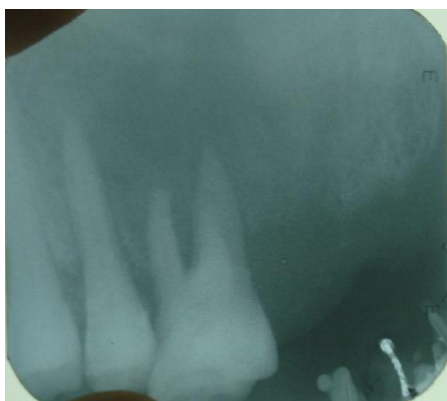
Maxillary lateral occlusal radiograph showing soft tissue radiolucency with specks of calcification and radiolucency with mixed radiopacity involving apex of left maxillary second premolar and left maxillary first molar
